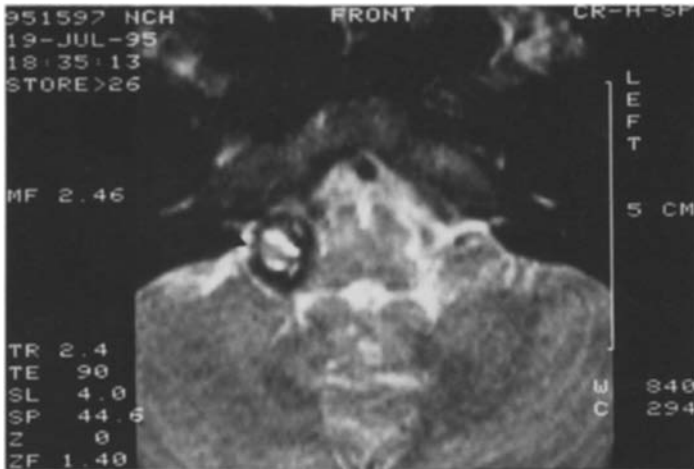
MRI (T2 weighted images) showing an hyper-ipointense cerebellopontine angle lesion with hypointense rim. Arrowhead indicates right VIIIth cranial nerve.
